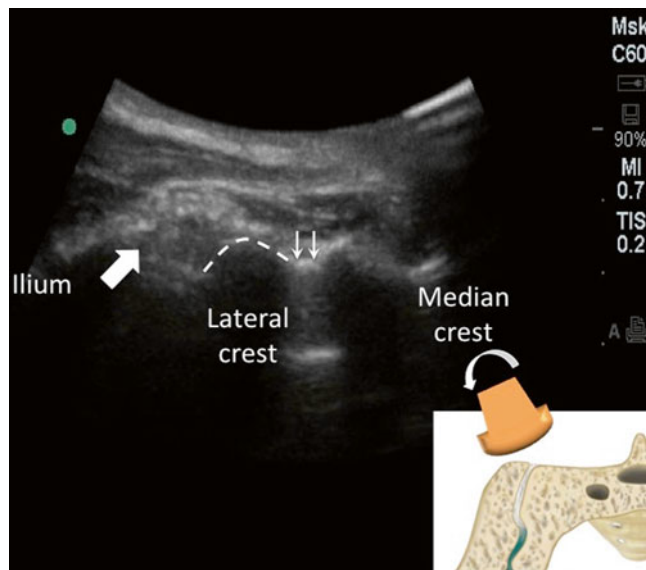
Sonography of the lower sacroiliac joint (SIJ) similar to Fig. 48.10 but the ultrasound probe was tilted toward the midline to allow a steeper angle of the needle. The probe position was indicated in the insert in the lower right corner. The SIJ was indicated by the bold arrow (Reproduced with permission of Philip Peng Educational Series)
